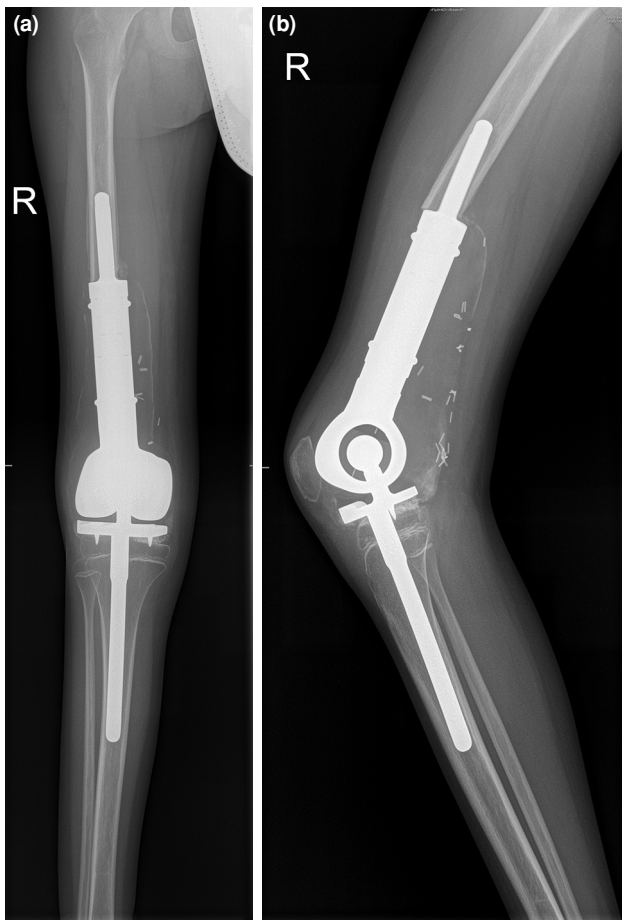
Direct radiographs show early signs of loosening. (a) Anteroposterior radiograph (b) lateral radiograph.
